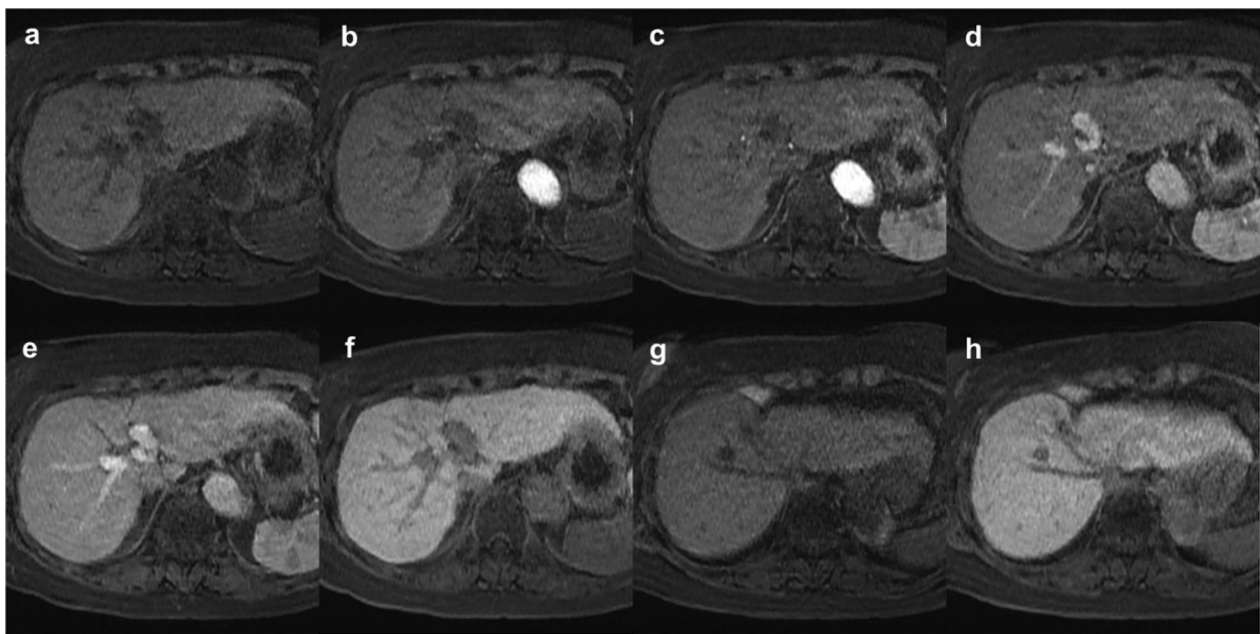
Representative images of an 85-year-old female with chronic hepatitis B who underwent magnetic resonance imaging (MRI) using both protocols, same as the patient in Fig. 8. MR images acquired with the 6-s scan protocol (a, pre-contrast; b, first arterial phase; c, second arterial phase; d, third arterial phase; e, portal venous phase; f, hepatobiliary phase; g, pre-contrast; h, hepatobiliary phase) are shown. Images a–f were acquired at the level of the posterior segmental branch of the portal vein, whereas images g and h show the level of the right hepatic vein (RHV). The average visual score for each item is as follows: the outline of the liver (pre-contrast, 1.5; first arterial phase, 2.5; second arterial phase, 2.5; third arterial phase, 2; portal venous phase, 3; and hepatobiliary phase, 3.5); RHV (pre-contrast, 2 and hepatobiliary phase, 2); portal vein, 2.5; hepatic artery (first arterial phase, 1; second arterial phase, 2; and third arterial phase, 2); and overall image quality, 2. The optimal arterial phase was obtained in the third arterial phase
